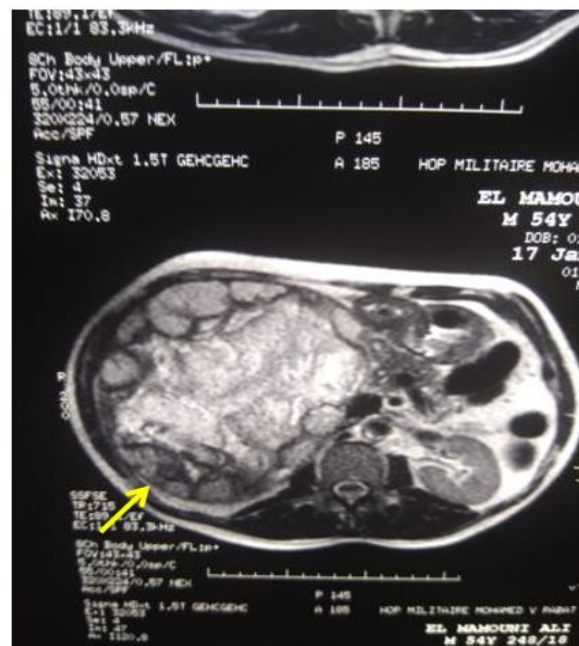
Abdominal MRI showing a large multilocular cystic mass in the right adrenal gland
